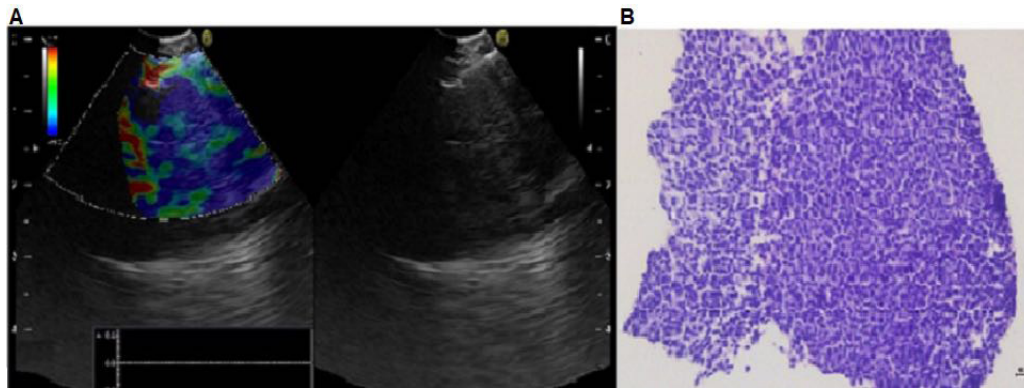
(A) Endobronchial ultrasound with elastography of the hypoechoic lymph node aspiration with a 22G needle in correspondence of the right lower paratracheal station and right hilar station. The elastography showed a predominantly blue pattern suspected for malignant lymph node. (B) Undifferentiated small round cell neoplasm consisting of relative monomorphic elements cohesive with hyperchromatic nuclei and poor eosinophilic cytoplasm (All images are 20× magnification).
